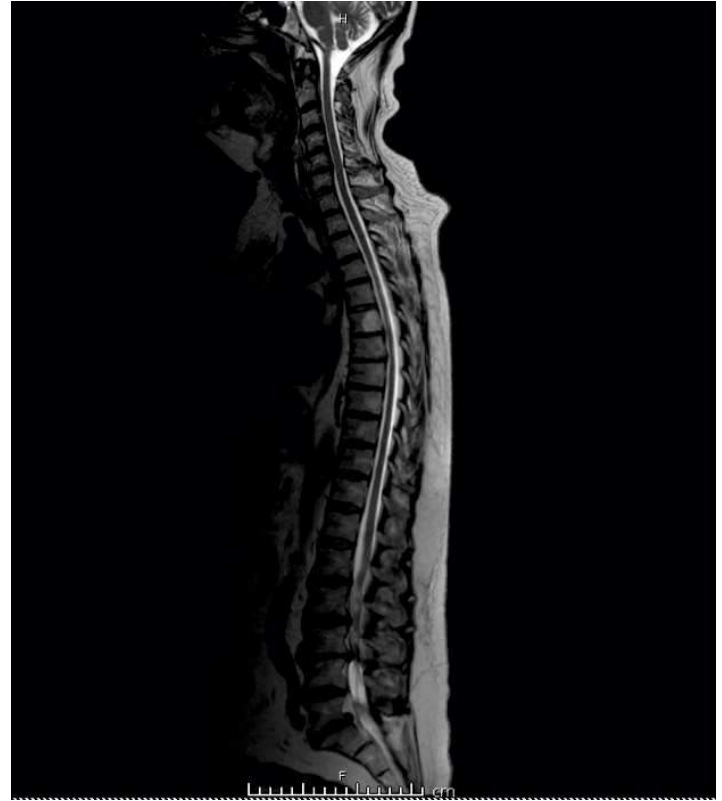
Sagittal T2 MRI of the spine
